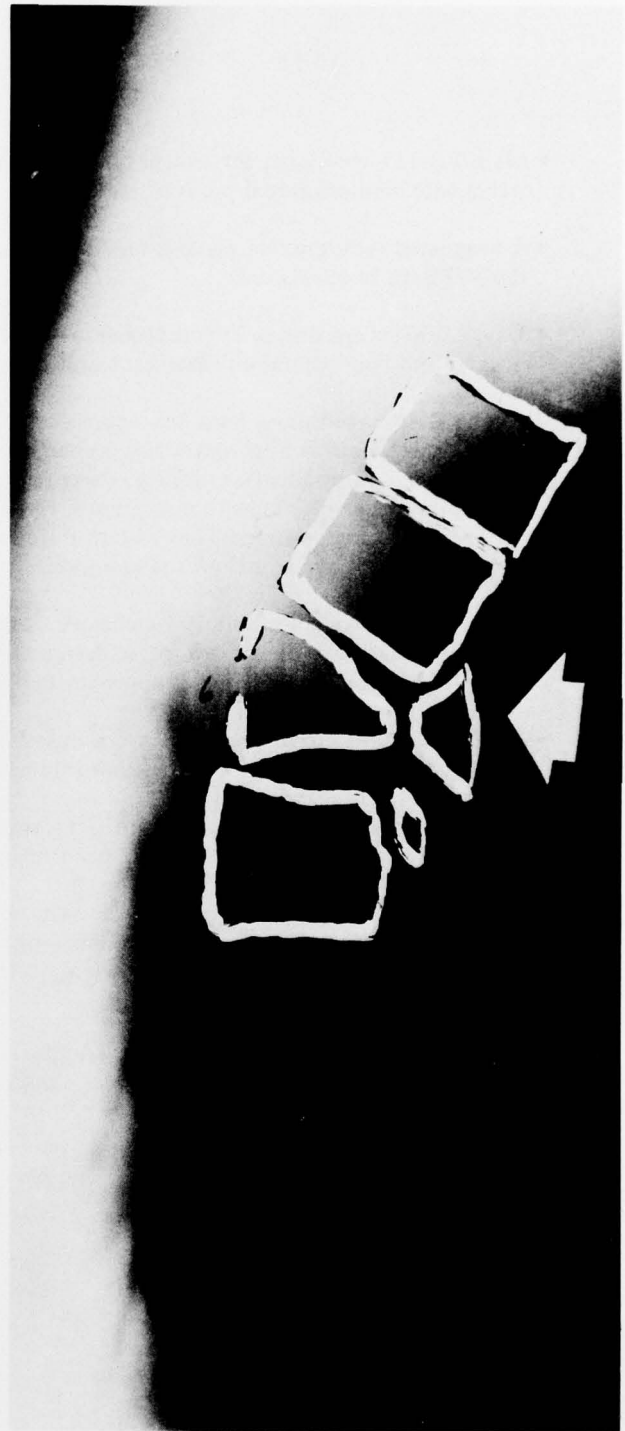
Lateral Roentgenogram of Subject TI 64 Weeks After Ejection [Bony Fusion is Noted to be Occurring]
